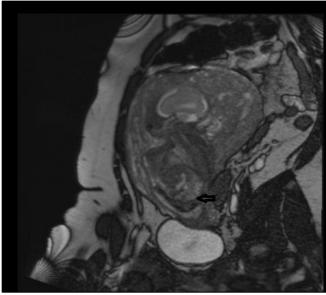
Oblique Sagittal Section of Fetus in Breech Position, Empty Bladder Compartment. (MRI T2 Sequence)
